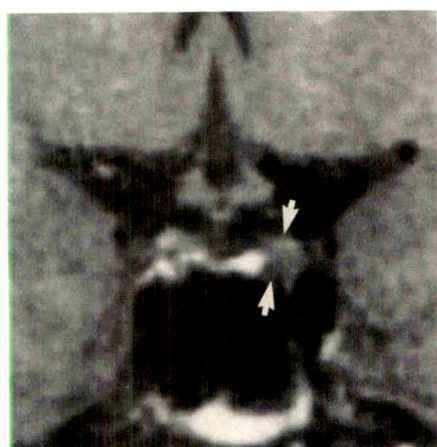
32-year-old woman 2 years after transsphenoidal surgery for Cushing disease. Persistent symptoms initiated reevaluation. T1-weighted coronal image, 600/20, was prospectively called normal with a midline stalk. In retrospect, there is a well-defined 4-mm low-intensity focus on left adjacent to cavernous sinus (arrows). Preoperative inferior petrosal sinus sampling showed abnormal ACTH elevation on left. At surgery, low-intensity focus corresponded to 4-mm left-sided ACTH-secreting adenoma. (Right half = true negative; left half = false negative.)
